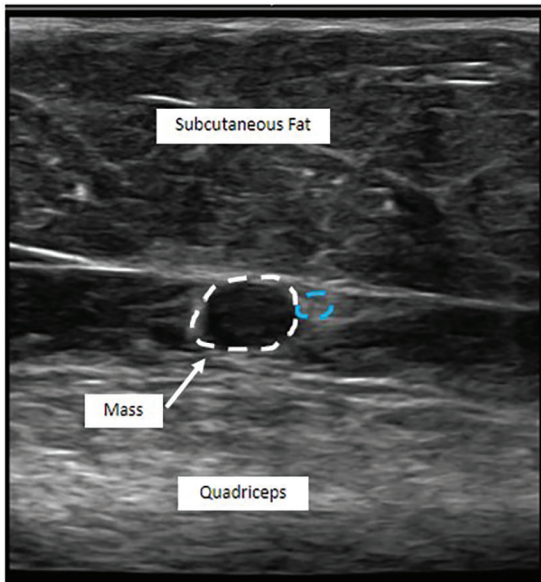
Ultrasonography of the 0.5 cm noncompressible, painful hypoechoic mass located near the anterior femoral cutaneous nerve. Dotted white circle demonstrates the mass. Dotted blue circle demonstrates the anterior femoral cutaneous nerve.
